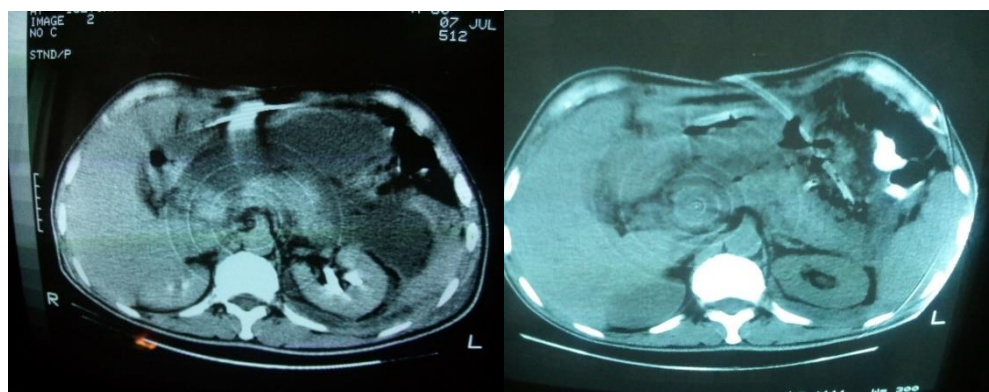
CT scan before and after PCD intervention (A-peripancreatic fluid collection along the whole anterior of pancreas B-most of fluid collection were drained out and small amount of solid debris was left in the pancreatic tail, White arrow shows drain).
